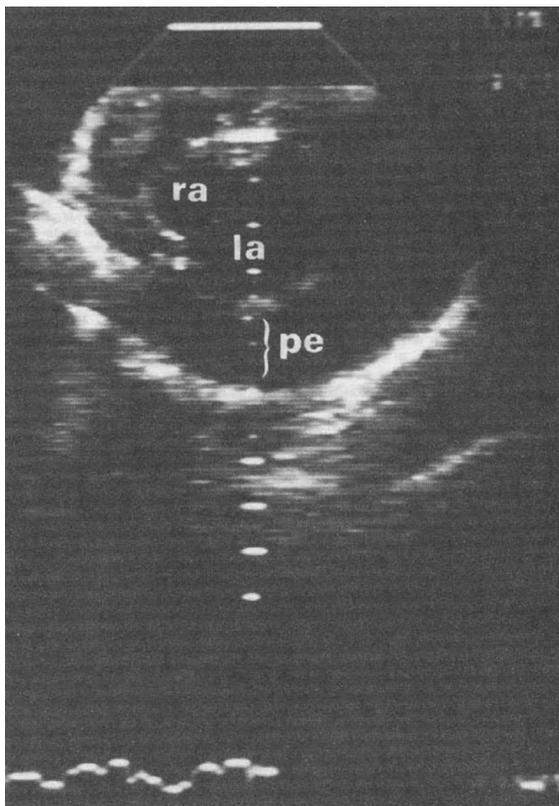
Two-dimensional echocardiogram in the subcostal four-chamber view showing 1.5 cm pericardial effusion (pe). la = left atrium, ra = right atrium.
